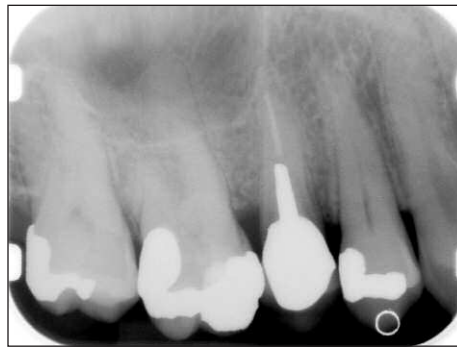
The initial radiograph does not reveal the cause of the patient's symptoms.
